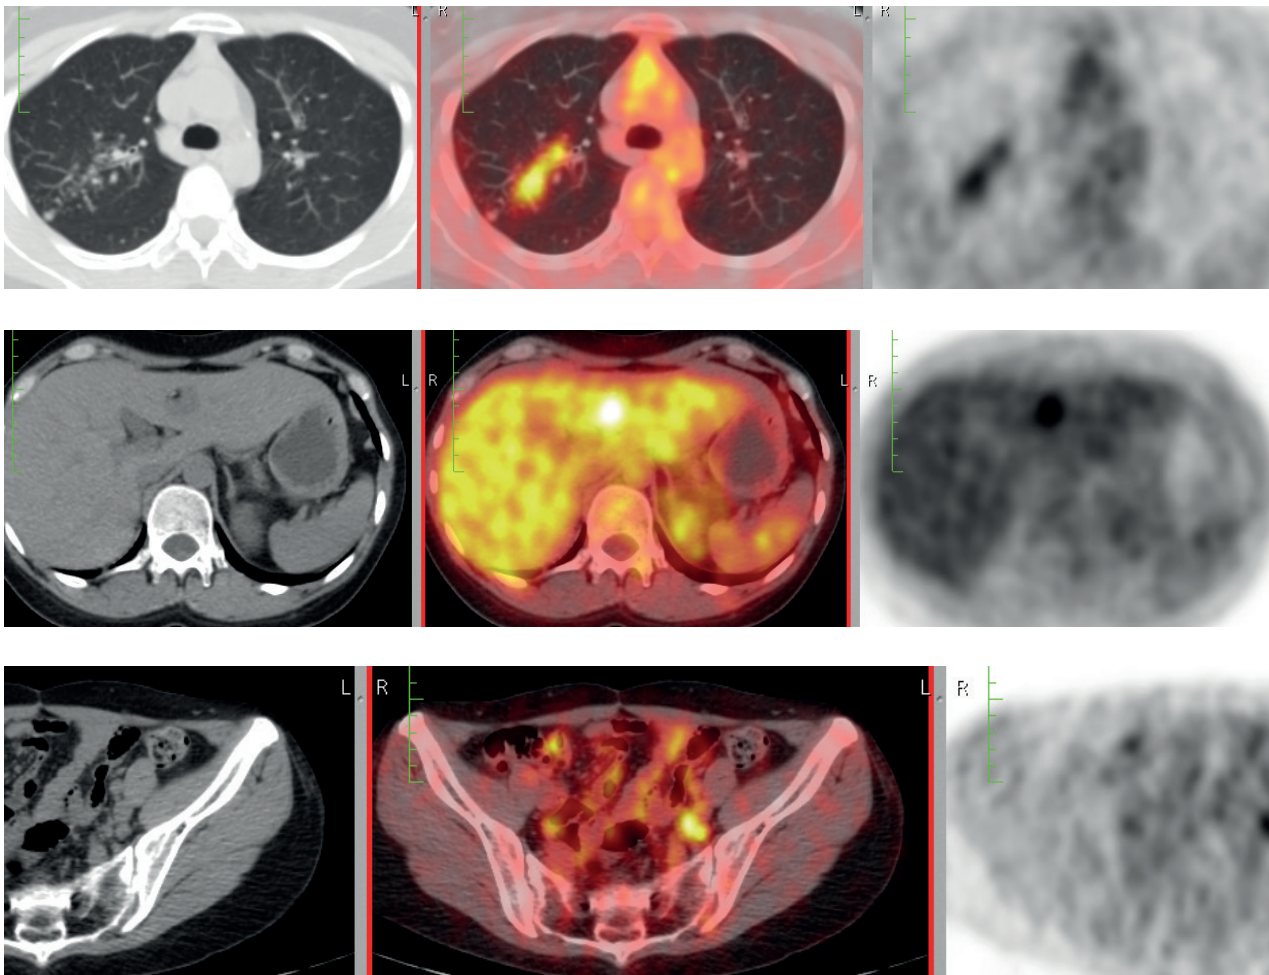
Axial non contrast-enhanced CT (left), fused PET/CT (middle) and FDG PET (right) images show metastatic disease in the lung, liver and pelvic lymph nodes.
